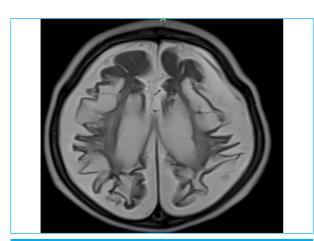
Axial T2 MRI shows gross atrophy (shown by white arrows) of the bilateral cerebral hemispheres involving bilateral frontal, parietal and occipital lobes along with loss of white matter. Multiple variable sized cystic spaces seen in the bilateral periventricular white matter suggesting encephalomalatic/gliotic changes.
